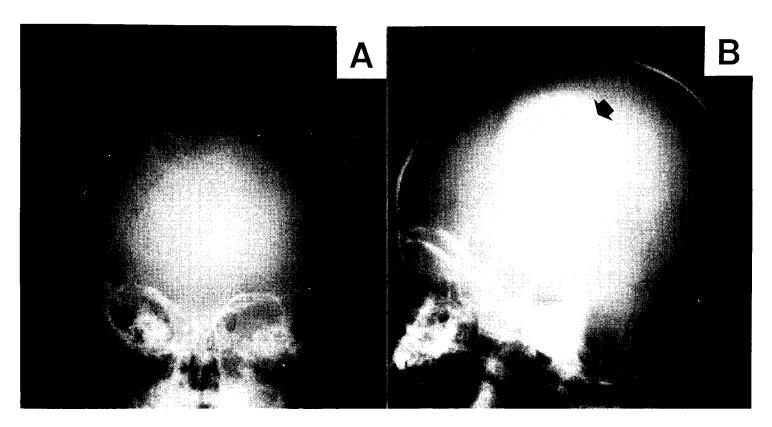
Preoperative skull X-ray: Towns' view(A) shows right occipital and lateral view(B) parietal radiolucent lesions with smooth borders and marginal sclerosis(arrows).
